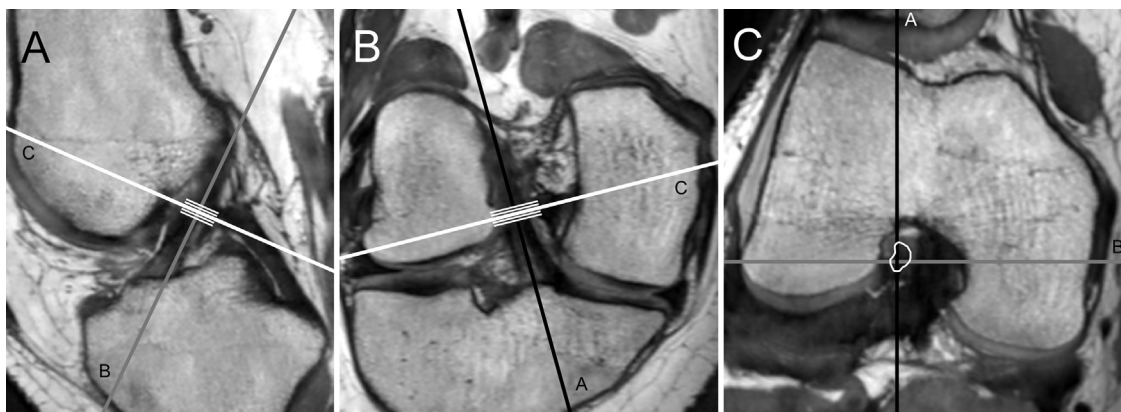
Example measurement of ACL CSA. MR images were resampled along the longitudinal axis of the ACL to provide two parallel (A and B) and one perpendicular (C) views. The ACL CSA was outlined in the perpendicular slice. Five total perpendicular slices were averaged together to determine ACL CSA at the midpoint. Abbreviations: CSA, cross-sectional area; MR, magnetic resonance.
